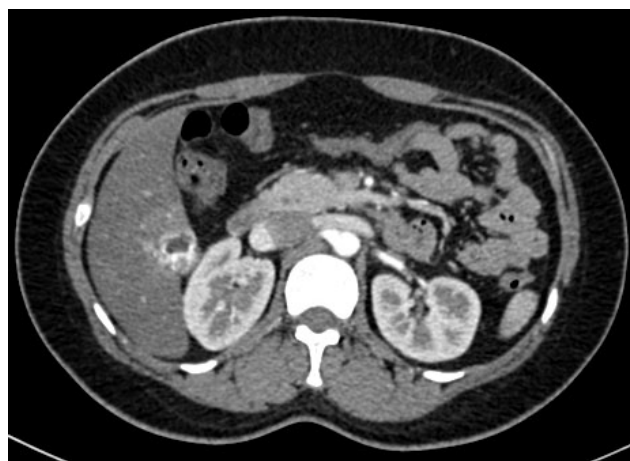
CT scan revealing a solid and cystic abnormal mass in the right lobe of the liver, and during the arterial phase, the enhancement of peripheral solid components of the lesion dramatically increased.
